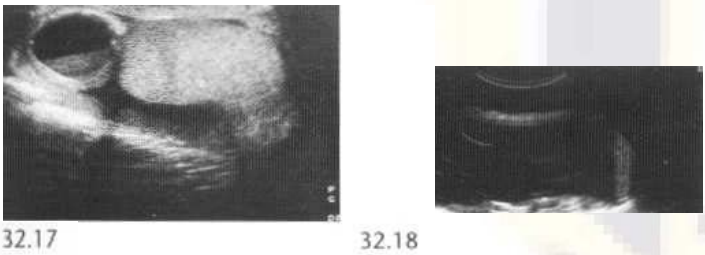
Ultrasound of infected epididymal cyst showing debris and fluid level.
